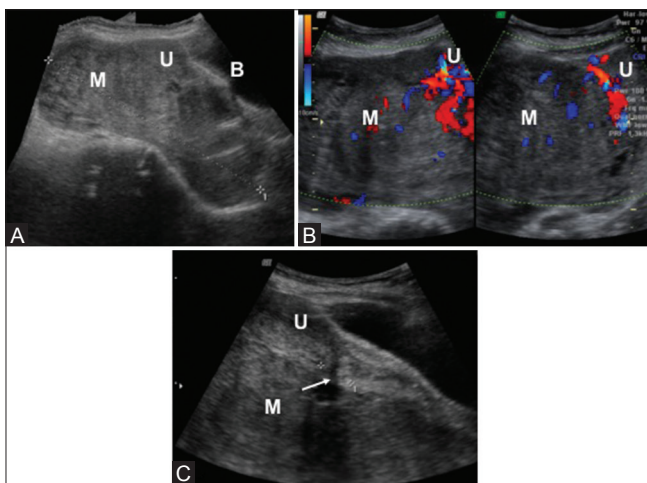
(A-C): (A and C) Transabdominal ultrasonography in sagittal plane shows a large mass predominantly isoechoic to the myometrium with peripheral heteroechoic areas related posteriorly to the uterus compressing the same with suspicious luminal communication (white arrow in C). (B) On Doppler USG, the mass shows prominent vascularity especially near its uterine attachment. (M –mass, U-uterus, B- urinary bladder)
